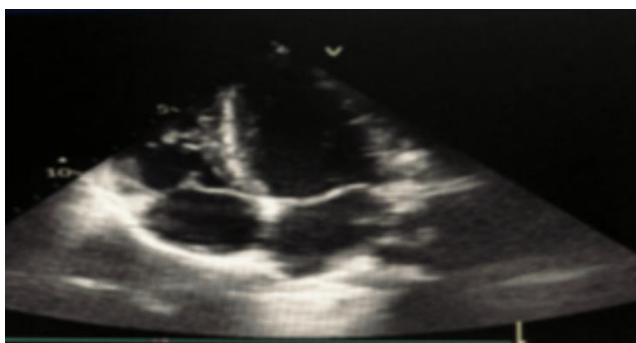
Shows Transthoracic echocardiograph
